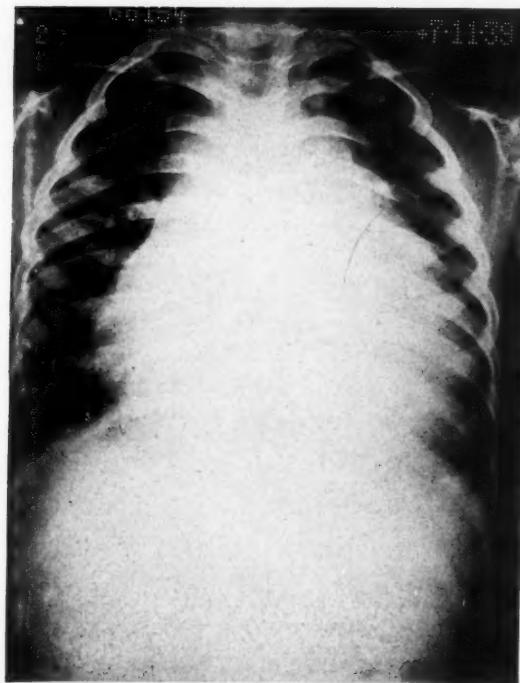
Case 7, July 11, 1939. Roentgenograph of the chest, showing massive tuberculous pericardial effusion before paracentesis.
